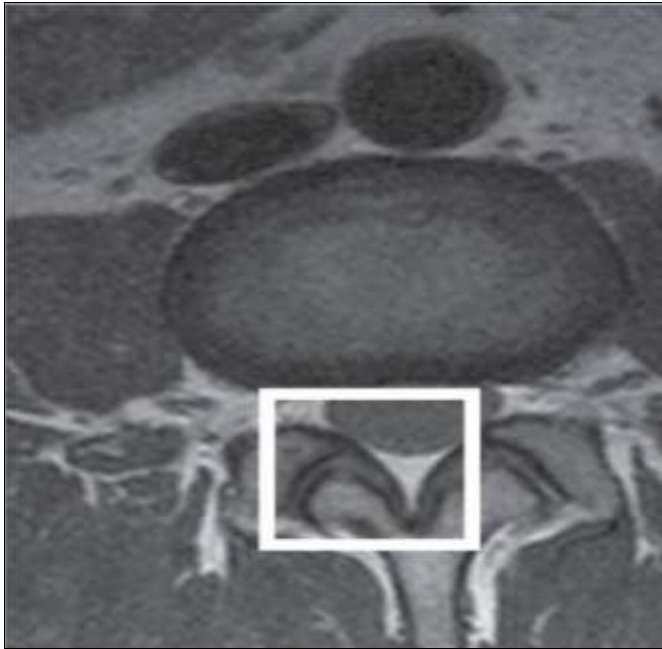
Magnetic resonance imaging performed in all included patients
